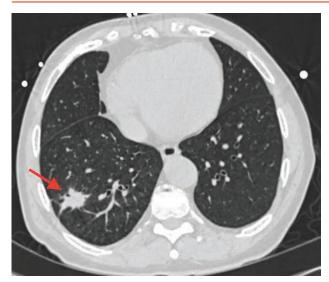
Solitary pulmonary nodule on chest CT (red arrow).
